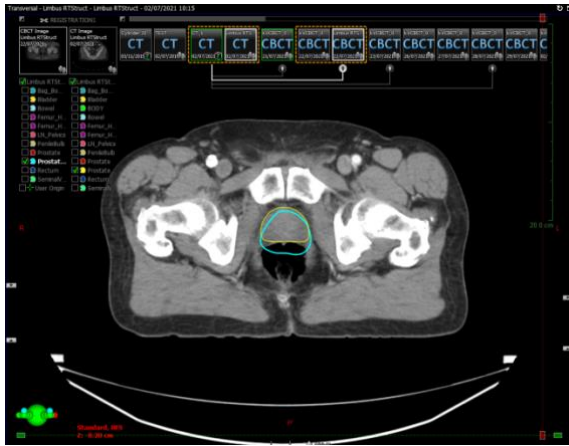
Axial slice of planning CT. Note distended rectum. Prostate contoured on planning CT in yellow. Prostate contoured on CBCT in turquoise.
